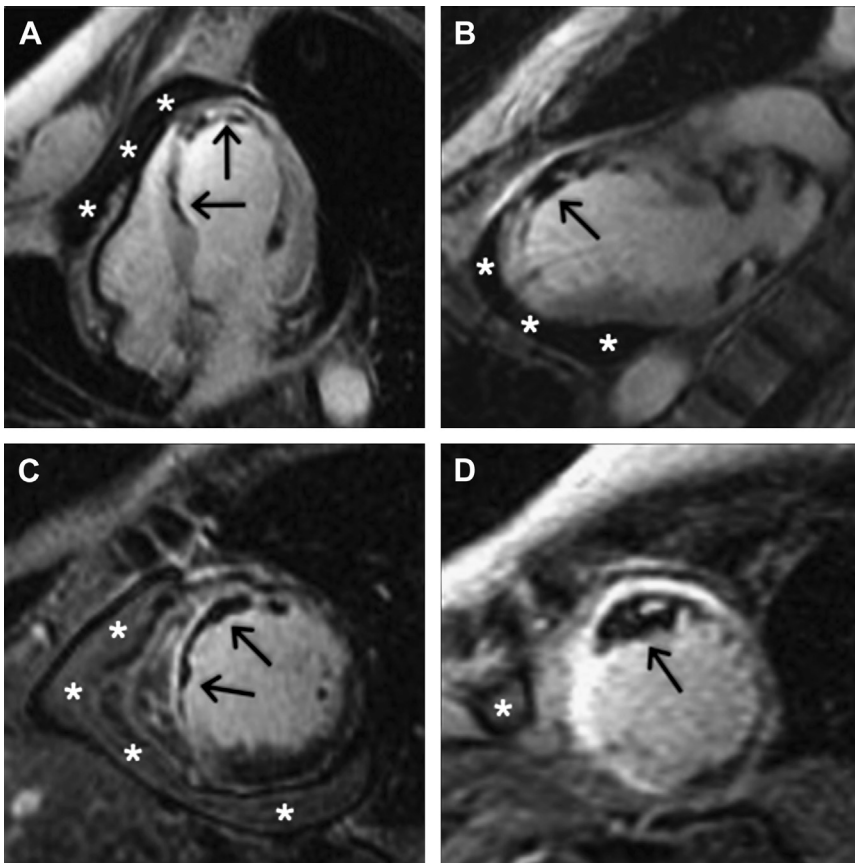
Extensive coronary artery disease imaged before potential coronary revascularization. EGE imaging (A, B) and LGE imaging (C, D) show LV dilatation with a laminated thrombus (arrows) extending from the midcavity to the anterior apex, adjacent to a transmural LAD infarction. A small pericardial effusion was present (asterisks). Previous echocardiography failed to depict the thrombus.
